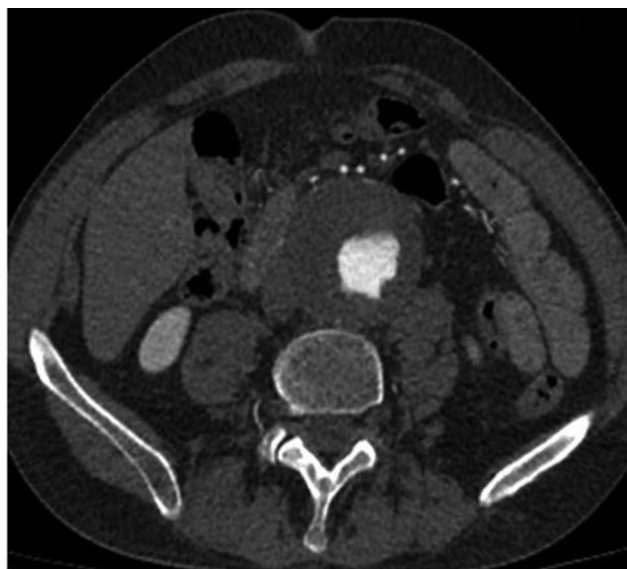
Axial view of the preoperative computed tomography angiography depicting the abdominal aortic aneurysm.
